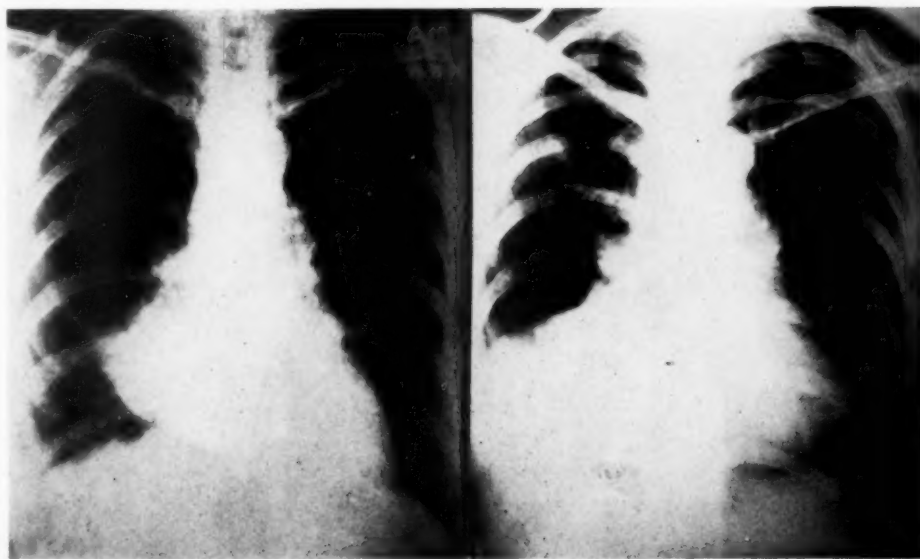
A roentgenogram taken six weeks prior to patient's admission, demonstrating the extension of the tumor from the base of the right lung—excluding the hepato-diaphragmatic origin.
